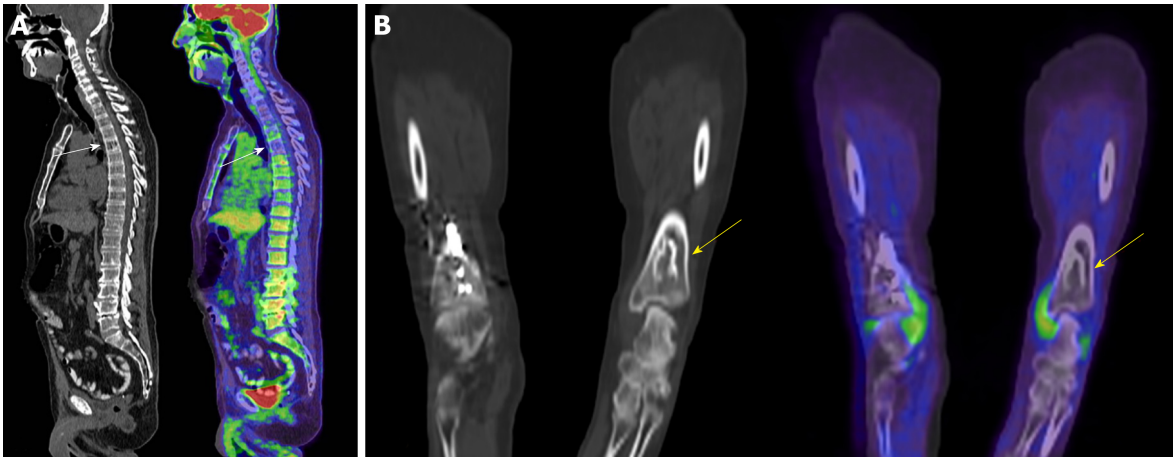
Computed tomography and fused positron emission tomography/computed tomography of two patients. A: Sagittal computed tomography (CT) and sagittal fused positron emission tomography (PET)/CT of the spine in a 73-year-old male with history of lymphoma and a hemangioma in the T5 vertebral body (arrows) [maximum standardized uptake value (SUV) 2.86]; B: Coronal CT and coronal fused PET/CT of the distal tibia in a 54-year-old female with history of a neuroendocrine lung tumor demonstrating a bone infarct (arrows) in the distal tibia (maximum SUV 0.37).
